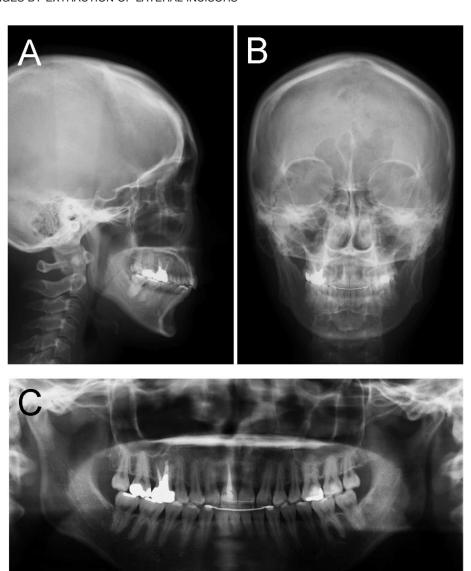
The 4-year retention cephalograms and a panoramic radiograph. (A) Lateral cephalogram. (B) Posteroanterior cephalogram. (C) Panoramic radiograph.
